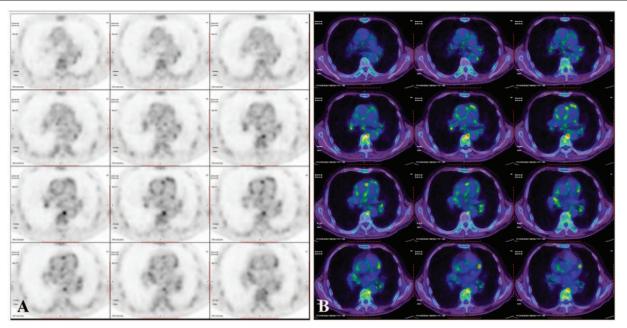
Fluro-deoxyglueose-positron emission tomography (A) and fused axial computed tomography (B) at baseline demonstrate diffuse, confluent radionuclide uptake in the walls of the ascending aorta, descending aorta, pulmonary aorta, the maximum standardized uptake value is 4.8.
